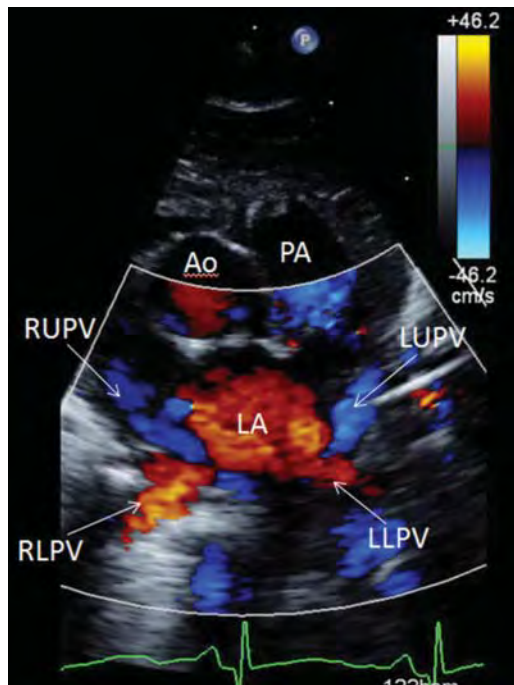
Parasternal imaging of the left atrium (LA) in the “crab view” provides identification of all four pulmonary veins. The left upper (LUPV), left lower (LLPV), right upper (RUPV) and right lower (RLPV) pulmonary vein are all identified by color flow assessment. The aorta (Ao) and pulmonary artery (PA) are visualized superior to the LA.
